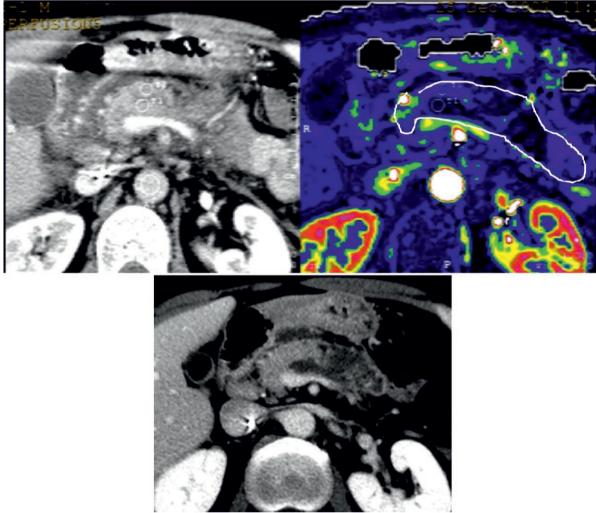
CE-CT and perfusion CT imaging in a patient with ANP. In upper panel, though CE-CT depicted poorly perfused area in pancreatic body, the extent of ischemic area was not clear. Perfusion CT showed ischemic changes of the pancreas and the extent of ischemic area clearly (black color in color map). Follow-up CE-CT demonstrated that ischemic area, which was detected in the initial perfusion CT, changed to be necrotic, but perfused area (blue color) was preserved (lower panel).
